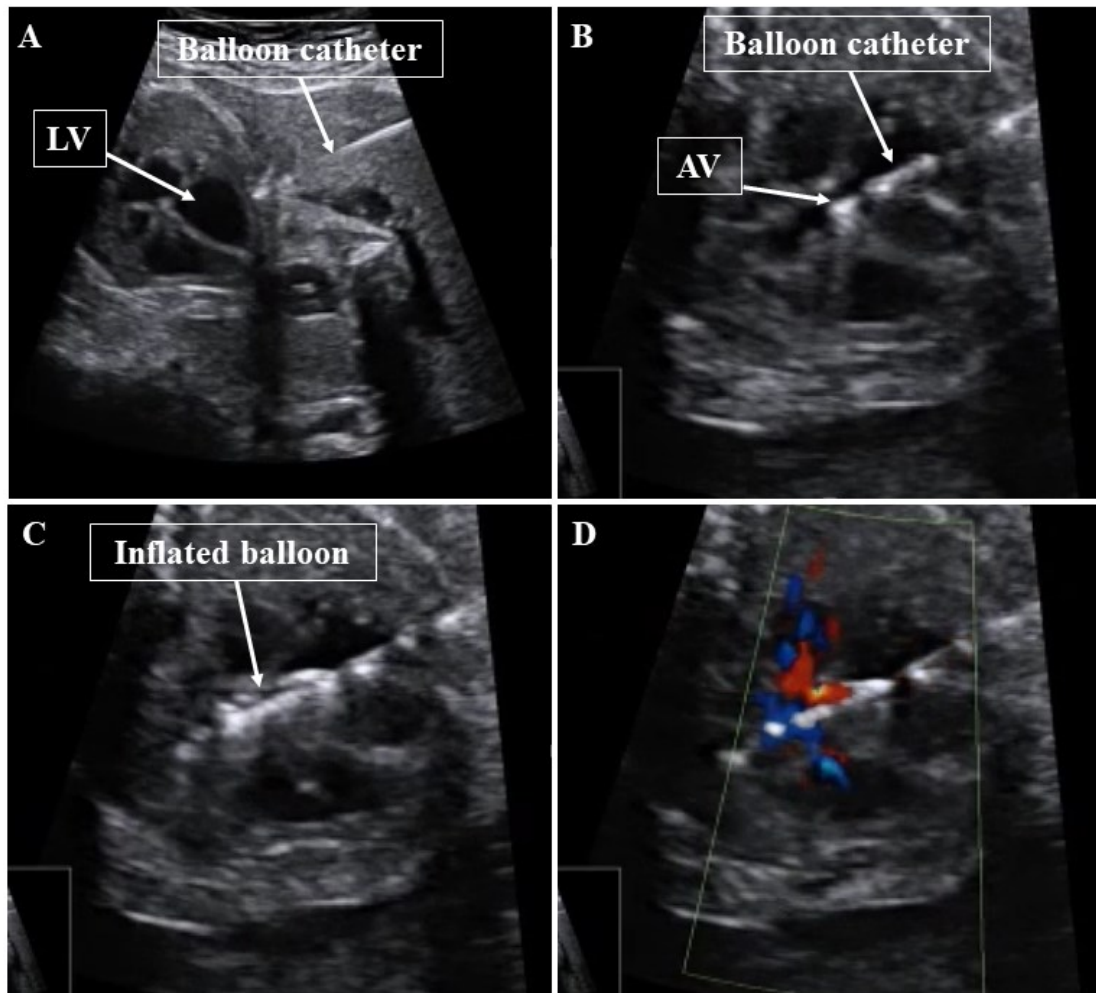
Overview of the stages of FAV intervention. [A] Balloon catheter is puncturing the fetal LV. [B] Under ultrasound guidance the balloon catheter is aligned in the fetal AV. [C] Once aligned in the AV the balloon is inflated to widen the stenotic AV. [D] Doppler velocity measurements are taken to assess the degree in which the stenosis has been relieved. Images taken from a video provided by Dr Gerald Tulzer.
